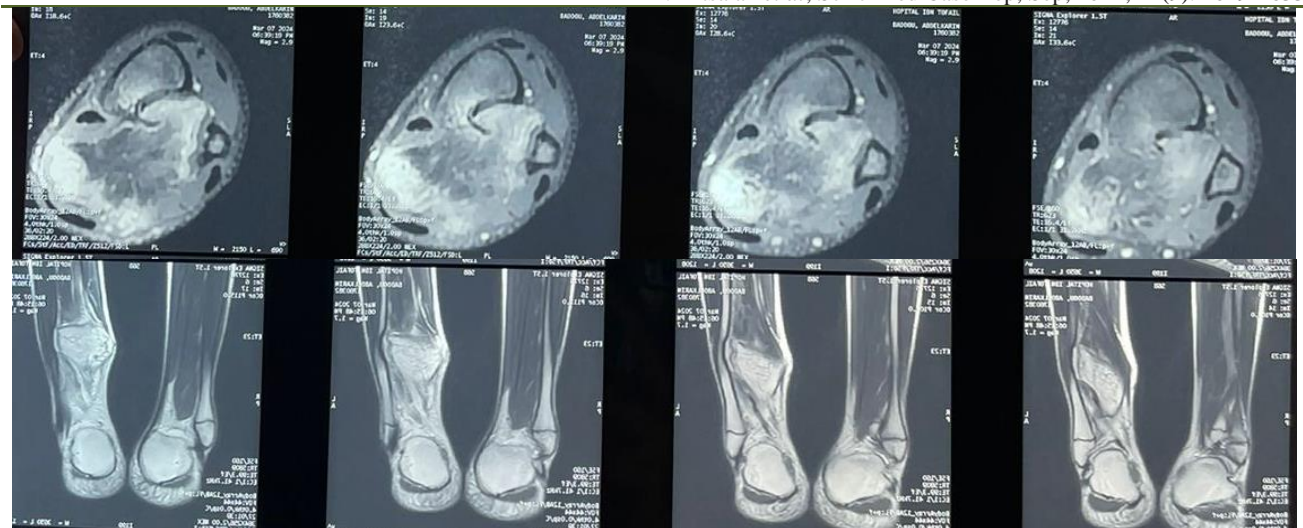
MRI views of the expansile tumor. (A and B) Coronal views. (C) Axial view of the distal tibiofibular region. Note the continuity between the cortex of the tumor and that of the parent bone (tibial metaphysis). Also, the fibular cortex
